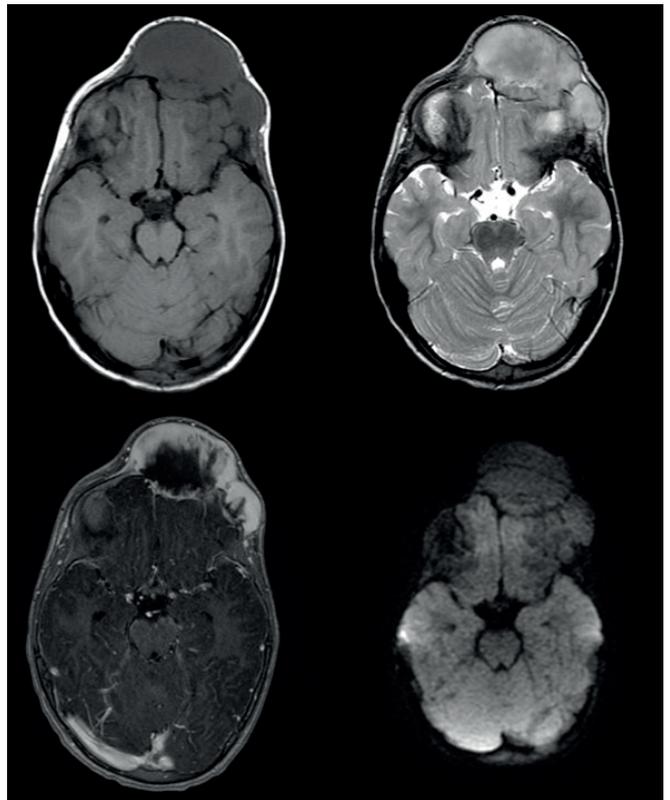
Image of the lesion in the magnetic resonance imaging (MRI) examination in the following sequences: T1 - weighted images (top left), T2 - weighted images (top right), T1 - weighted images after contrast agent administration (bottom left) and diffusion-weighted imaging - DWI (bottom right)
